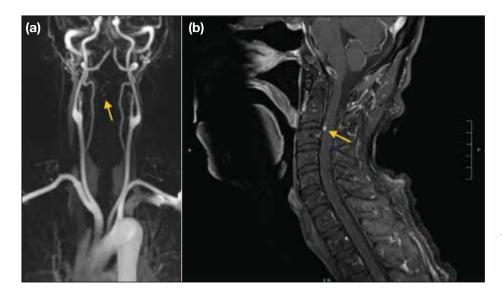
Time-resolved (a) magnetic resonance imaging angiography and (b) postgadolinium T1-weighted magnetic resonance imaging with fat saturation of the cervical spine. The radiculomedullary aneurysm (arrows) is demonstrated as an enhancing lesion in the spinal canal.
